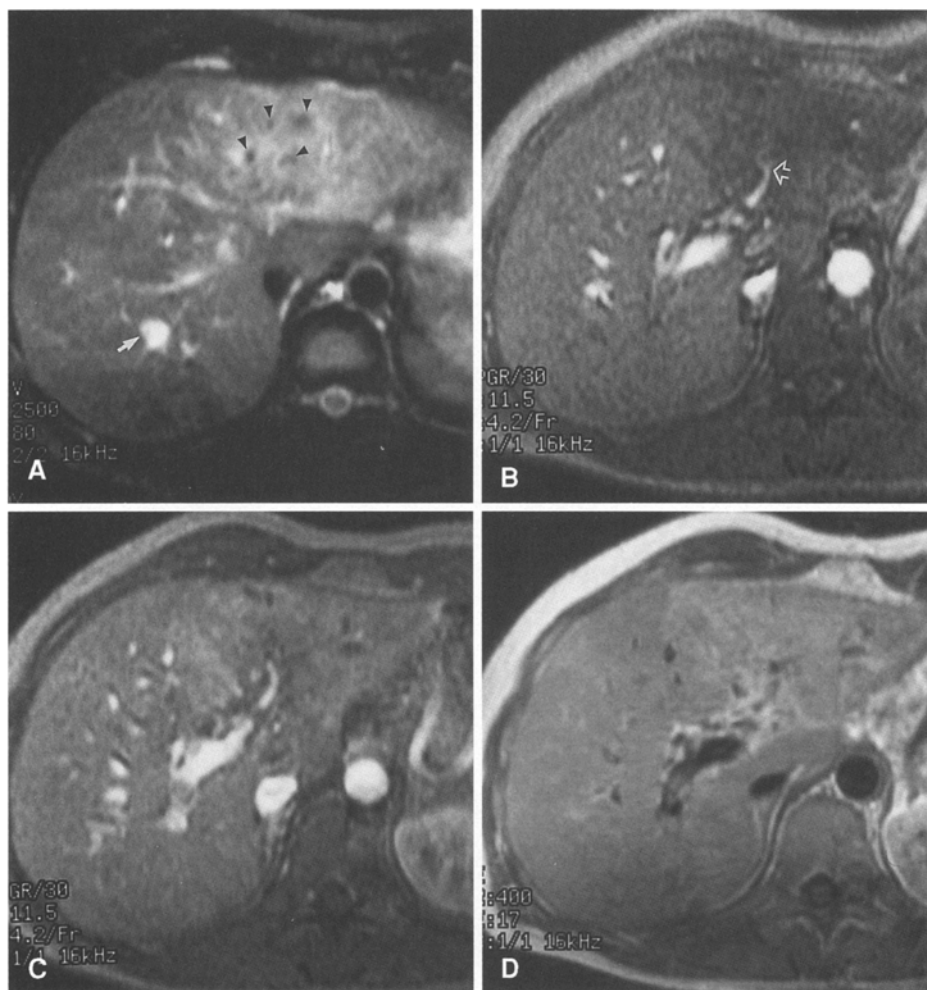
A 44-year-old man with intrahepatic cholangiocarcinoma. A T2-weighted (TR/TE = 2500/80 ms) spin-echo (SE) MR image shows moderately hyperintense ill-defined tumor. Dilated biliary ducts are present in the tumor (*arrowheads*). A small hemangioma is seen (*arrow*). B Gradient-recalled echo (FSPGR, TR/TE = 11/4 ms, flip angle = 30°) MR image obtained before IV shows portal encasement (*arrow*) by hypointense tumor. C Forty seconds after IV, the tumor displays mild peripheral enhancement. D On delayed T1-weighted SE MR image obtained 10 min after IV, the tumor shows complete but moderate enhancement compared to that of the liver.
